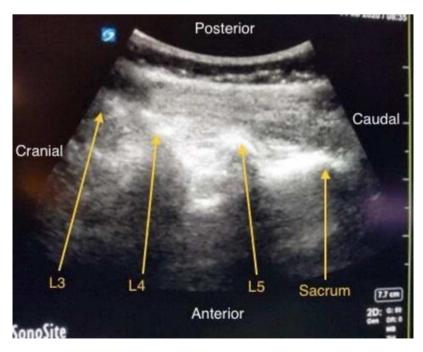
Ultrasound image of patient's vertebral column showing comminuted fracture at L3 spinal vertebra.
